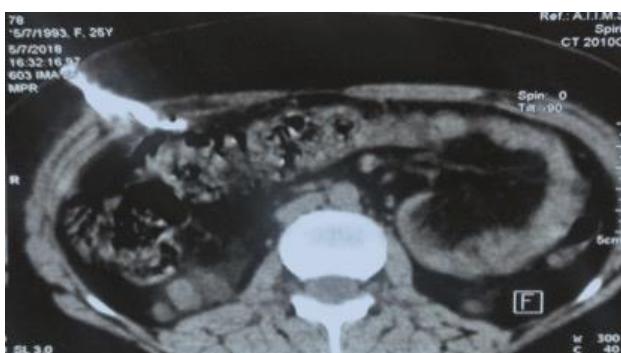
CT sinogram showing peritoneocutaneous fistula tract.
